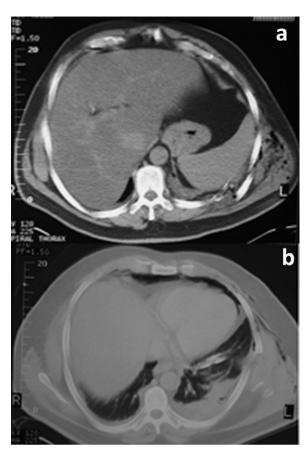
Computed tomography scan showing the splenic (a) and the lung injury (b).
